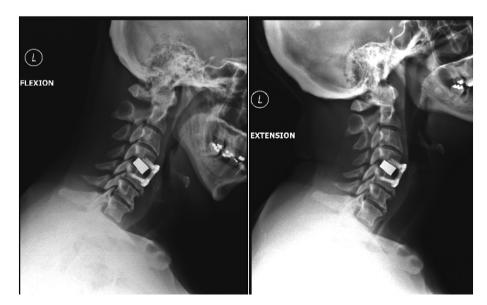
Flexion and extension cervical spine x-rays 4 months postoperatively demonstrating solid bony fusion at C4-C5 ACDF site.
